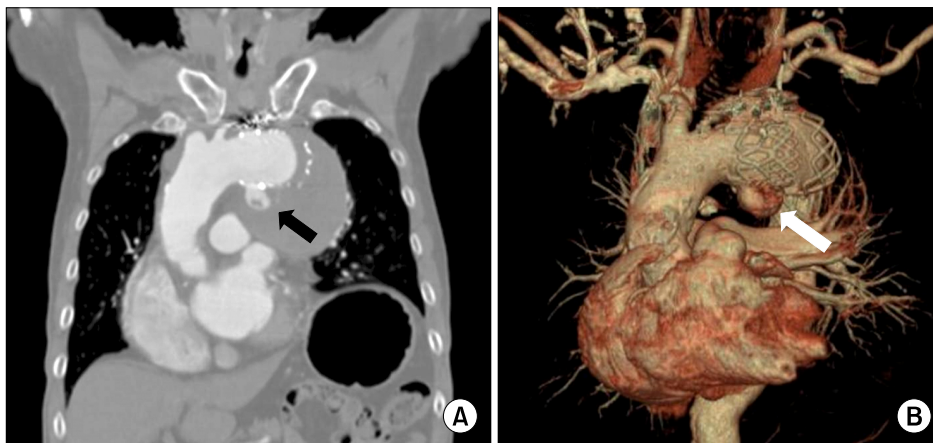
Preoperative images. (A) The coronal section of CT shows type I endoleak at the proximal portion of the previous stent graft (black arrow). The maximal diameter of the aneurysm is 86 mm. (B) 3-Dimensional CT angiography shows type I endoleak at the proximal portion of the previous stent graft (white arrow). CT, computed tomography.
